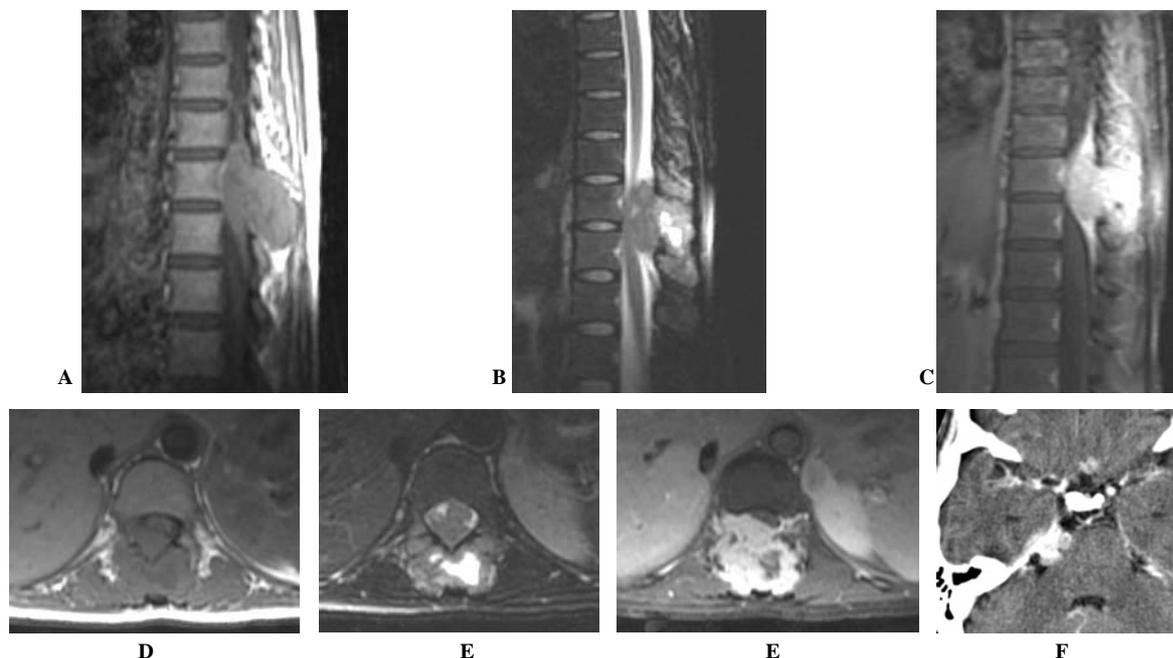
Case V: A 31-year-old woman, presented with right subcostal pain and low back pain. Sagittal and axial T1WI (A,D), T2WI with fat suppression (B,E) and post contrast T1WI with fat suppression (C,F) reveal irregular intraspinal-extramedullary, 5 cm-mass at the level of T11, infiltrated posterior element and T11 body, showing hypointensity on T1WI, inhomogeneous hyperintensity on T2WI with intense enhancement. Some areas of internal cystic or necrotic component is seen. The mass causes pressure effect and displacement of the adjacent spinal cord. Another mass with the same characteristics is observed at L4 level (not shown here). Follow up CT brain later discloses dense enhancing, extra-axial masses at the right cerebellopontine angle cistern
